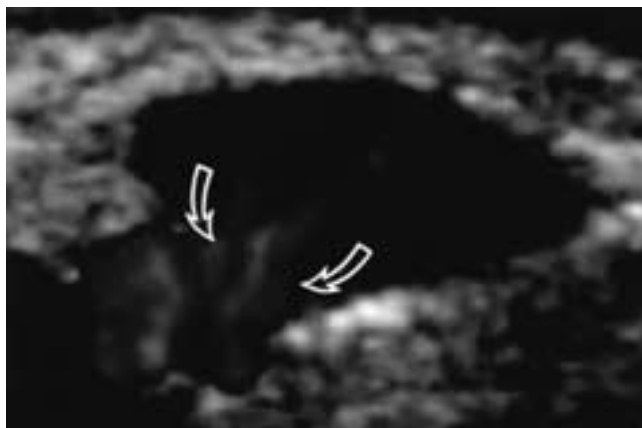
Power Doppler ultrasound shows hilar flow (arrows) inside a small normal lymph node, which is seen with low signal intensity.
